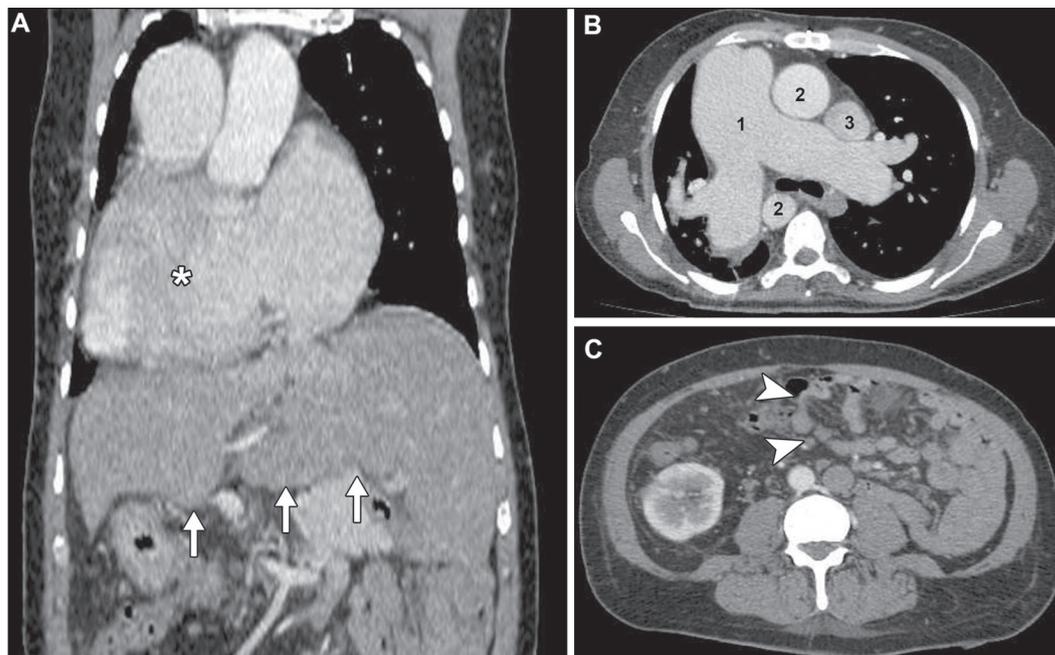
Contrast-enhanced CT scan. A: Coronal thoracoabdominal CT scan showing dextrocardia (asterisk) and a centrally located liver (arrows). B: Axial chest CT demonstrating enlargement of the right-sided pulmonary trunk, which measured 5.8 cm in its largest diameter (1), right-sided aorta (2) and left-sided superior vena cava (3). C: Axial abdominal CT showing abnormal intestinal rotation (arrowheads)—the entire small bowel is positioned to the left of the midline.
